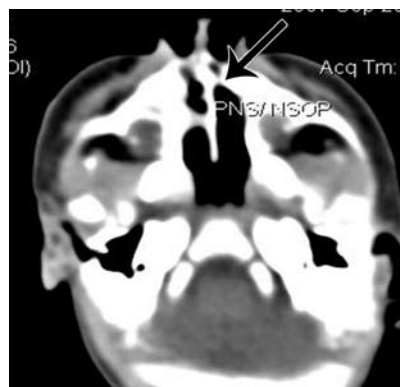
Axial, bone window CT cut. There is no evidence of choanal atresia and no abnormal airway.
